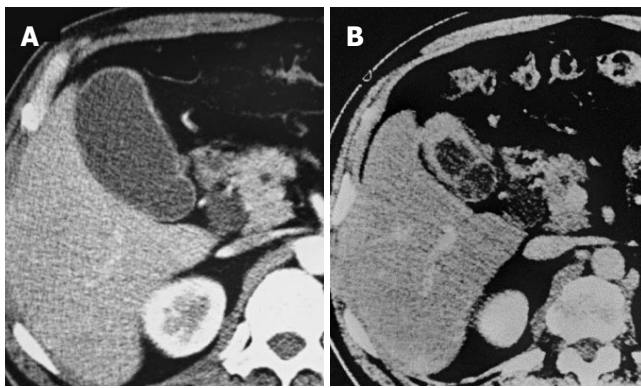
A: CT reveals diffuse thickening of the gallbladder wall and dilatation of the common bile duct to 14 mm; B: After 42 mo, CT reveals progressive thickening of the gallbladder wall, suspicious for gallbladder carcinoma.
